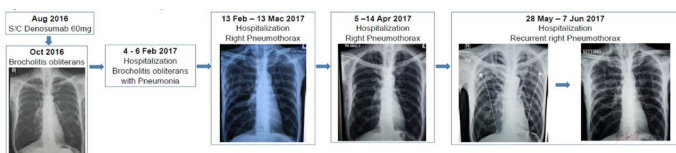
Patient’s chest x-ray from denosumab administration until occurrence of pneumothorax.
